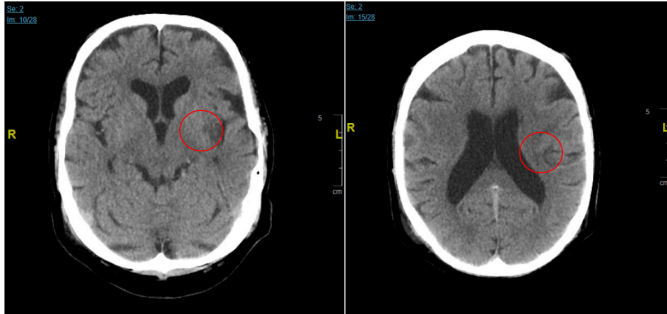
Mr. DC's Brain CT demonstrating areas of ischaemic infarction in the left Middle Cerebral Artery territory
